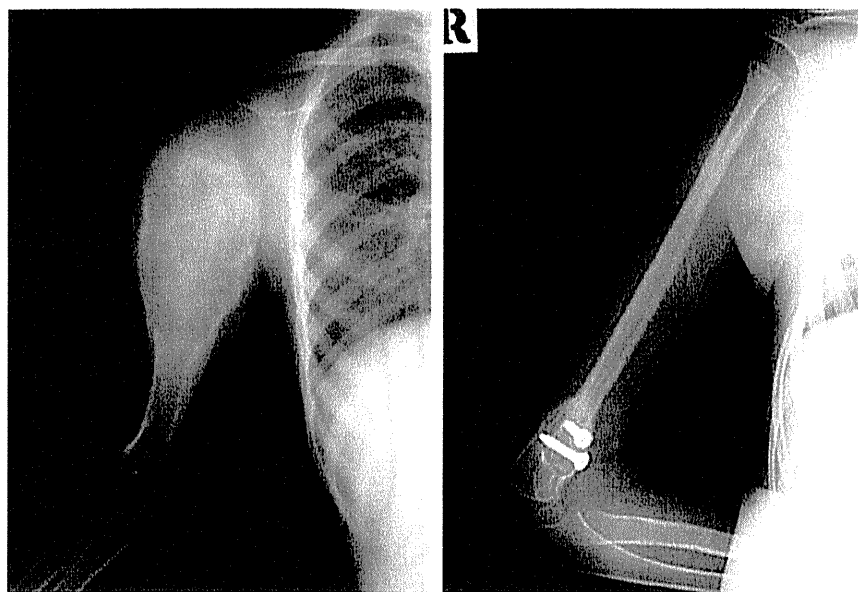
Patient 1, a 4-year-old boy, presented with chondrosarcoma of the proximal humerus. (Left) Preoperative radiograph showed a $10 \times 14 \times 7$ -cm tumor. (Right) Radiograph obtained 3 months postoperatively showed good ossification between the transferred and residual bone.
